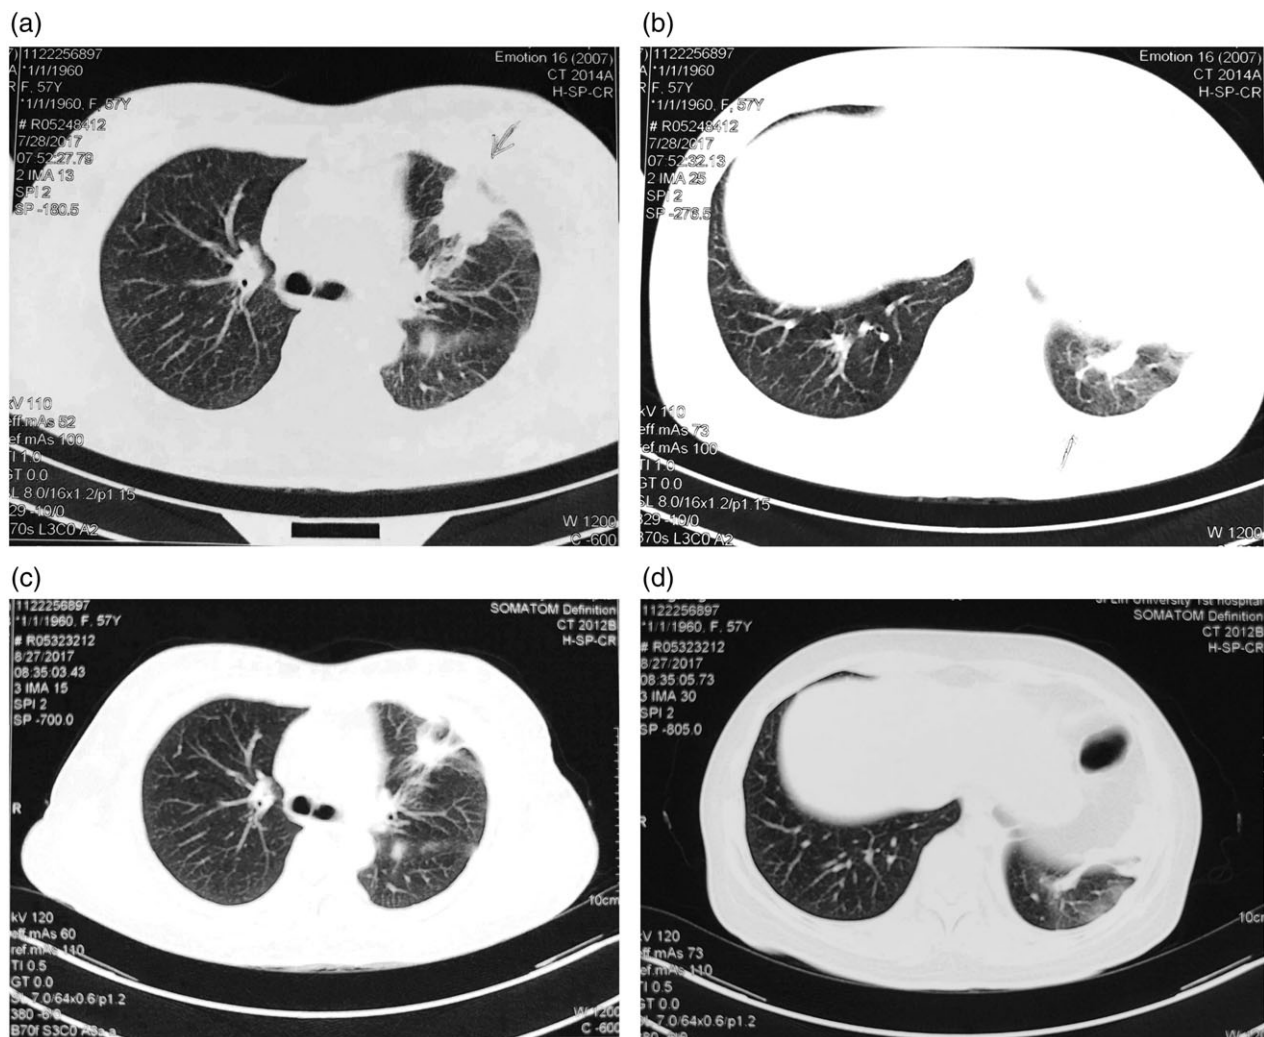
(a,b) Computed tomography (CT) images taken on 28 July 2017 when the patient arrived at our outpatient facility for the first time. Multiple lesions were observed on both sides of the lung. (c,d) CT images taken on 27 August 2017 after orally administration of afatinib 40 mg/day for one month. Shrinkage of the lesions was observed, particularly in the upper lobe of the left lung.
